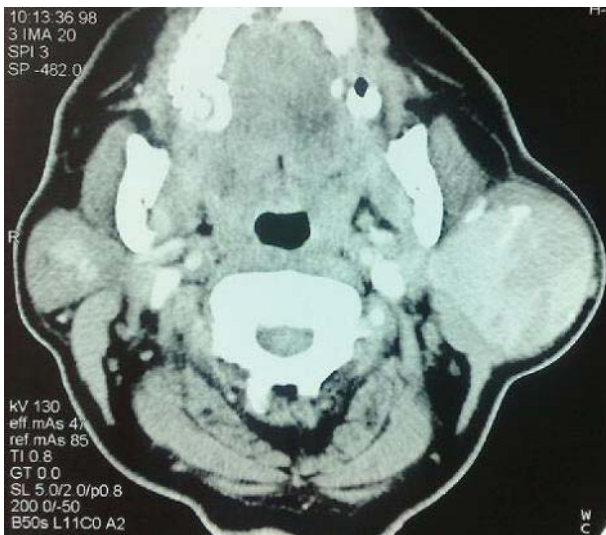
Preoperative CT scanning showing left parotid mass.
